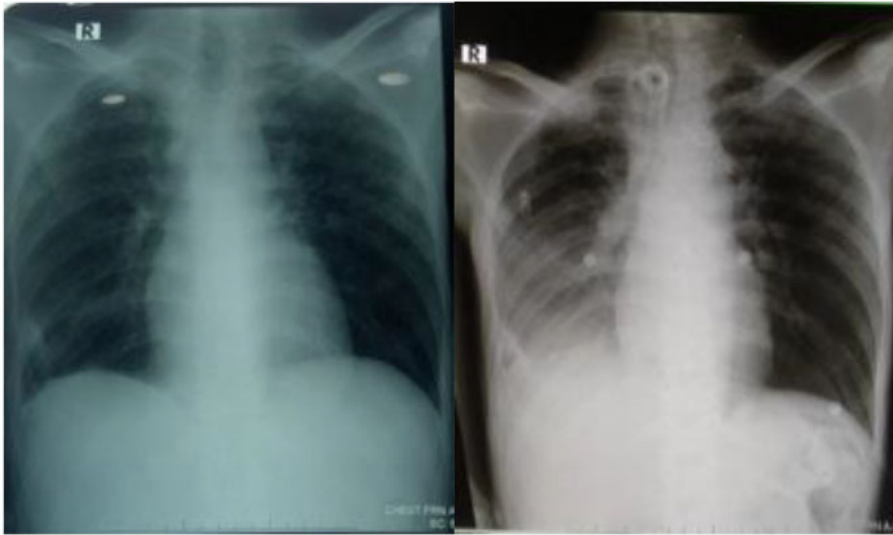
Chest X-Ray on first admission (Day 1) and readmission (Day 20).
